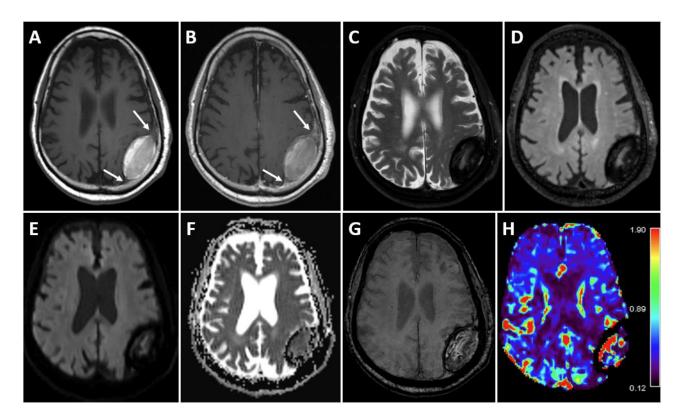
Axial T1-weighted (A), axial T1-weighted post-contrast (B), axial T2-weighted fat-suppressed (C), axial T2-weighted fluid-attenuated inversion recovery (FLAIR) (D), axial diffusion-weighted (E), axial apparent diffusion coefficient (F), axial susceptibility-weighted (G), and axial leakage-corrected cerebral blood volume maps demonstrate an extra-axial focus in the left parietal convexity. The lesion exhibits heterogeneous T1-hyperintense and T2-hypointense signal characteristics, with minimal enhancement on the post-contrast T1-weighted sequence. Uplifting of the dura along the anterior and posterior aspects of the lesion is noted, with subtle enhancement (A and B, white arrow). The lesion also shows susceptibility artifacts. Dynamic susceptibility contrast (DSC) perfusion imaging indicates increased relative cerebral blood volume (rCBV); however, due to the presence of susceptibility artifacts, this finding is likely artifactual. Given the subtle heterogeneous enhancement within the lesion and along its anterior and posterior aspects, the leading differential diagnosis includes calcified meningioma or a hemorrhagic extra-axial lesion, with other possibilities including a calcified walled-off extra-axial hemorrhage or a metastatic lesion.
